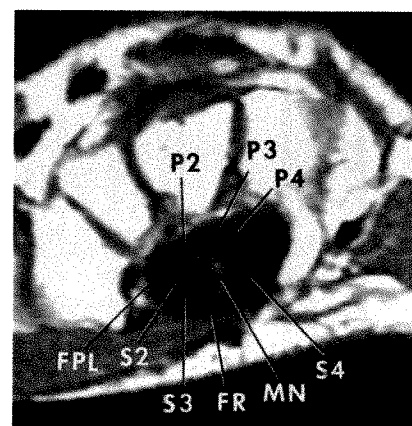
MR image (600/20) of flexed wrist shows median nerve interposed between and deep to sublimis tendons 2 and 3, immediately volar to profundus tendons 2 and 3. (See key for abbreviations.)
